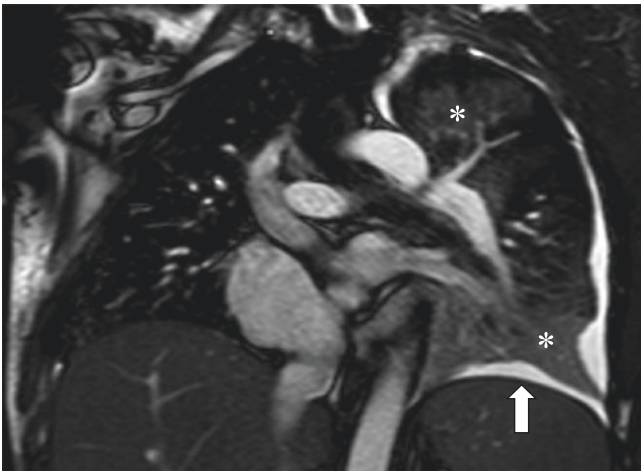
Bacterial bronchopneumonia in a 16-year-old girl who presented with fever and cough. Coronal non-enhanced TruFISP/FIESTA MR image shows peribronchial ground-glass signal abnormality in the left upper and left lower lobes (asterisks) and a simple left pleural effusion (arrow)
